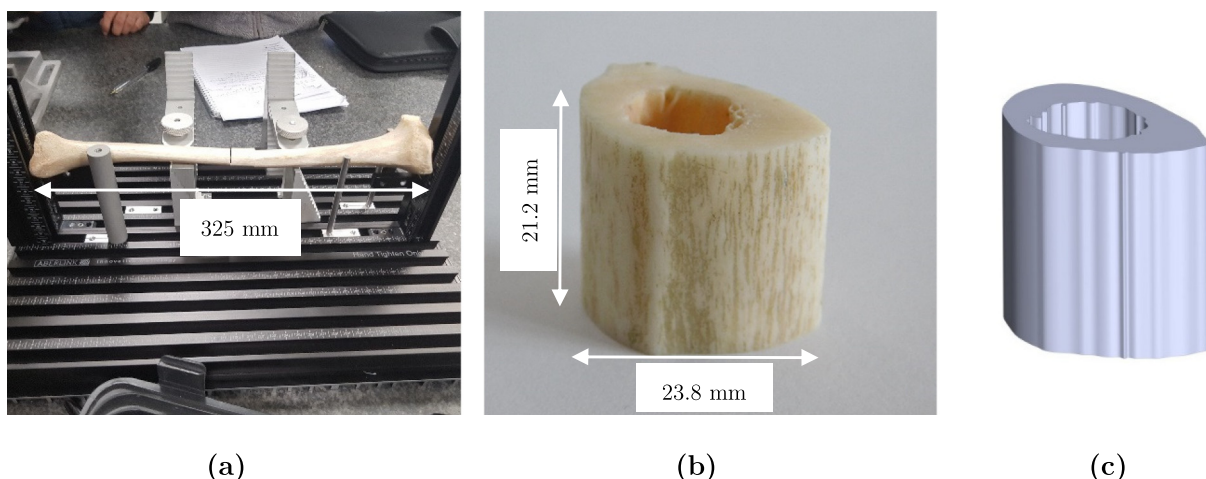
Anatomical profile generation showing (a) tibial bone considered, (b) segmented section and (c) fully dense CAD bio-model based on X-Ray CT Scan data of the segmented bone.
